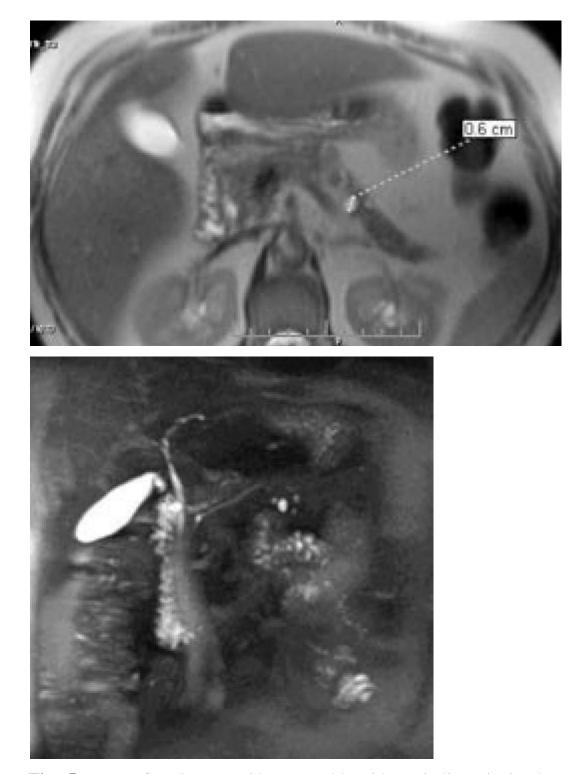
MRI of patient B., 32 years old, with periodic pain in the upper abdomen, a history of attack of acute pancreatitis: a - T1-VI with the suppression of signal from fat tissue in the axial plane, the size of the head of the pancreas increased slightly (2.9 cm), the signal from the pancreatic parenchyma with small foci of low signal on fat replacement acinar tissue (arrowheads), the size of the body and tail are reduced due to atrophic changes at the rear edge of the body of the pancreas is rendered small cystic formation with a diameter of 0.6 cm (large
